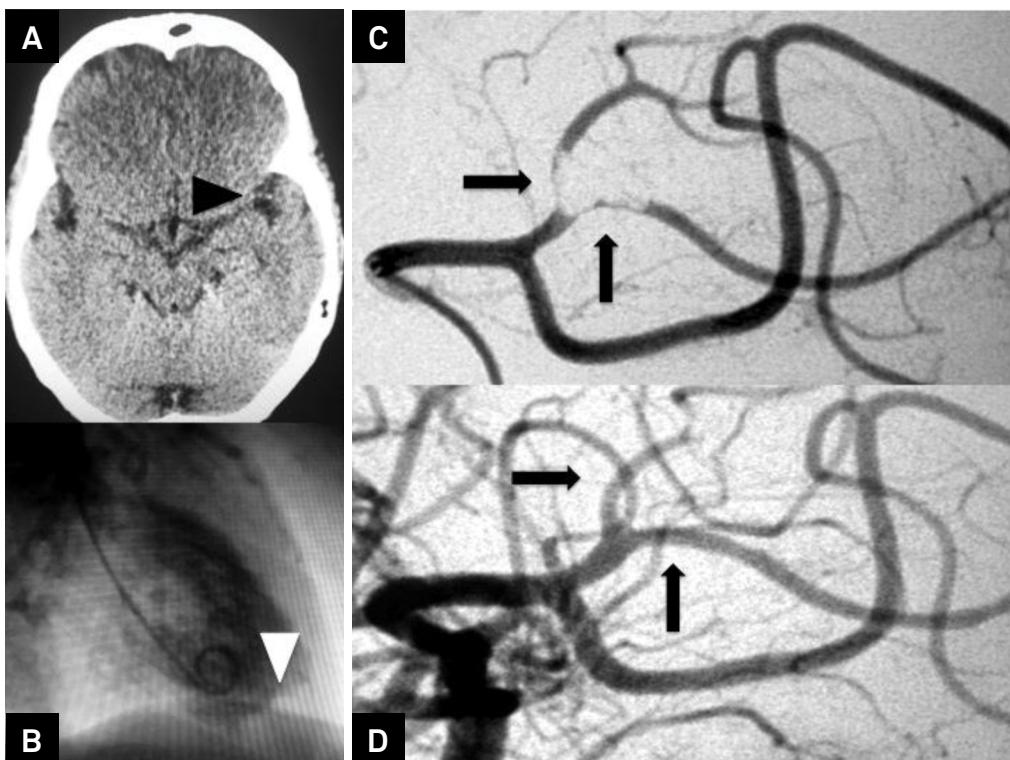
(A) Computed tomography demonstrated a left middle cerebral artery "dot" sign (arrowhead); (B) Coronary angiogram revealed an apical myocardial dysfunction with a large thrombus; (C) Cerebral angiogram demonstrated an occlusion; (D) Recanalization after an endovascular procedure using a mechanical device (Penumbra system).
